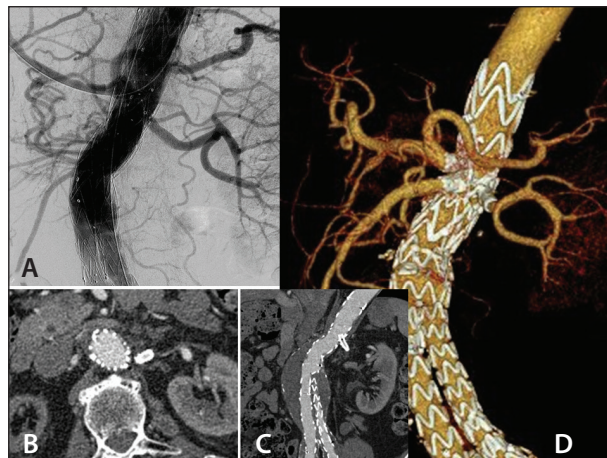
Final angiography confirmed exclusion of the endoleak as well as successful connection to the target visceral vessels (A). Postinterventional CT scan (axial orientation and curved multiplanar reconstruction) prior to discharge confirmed exclusion of the type Ia endoleak (B, C). A 3D reformation of the CT scan confirmed correct position of the connecting stent grafts (D).
